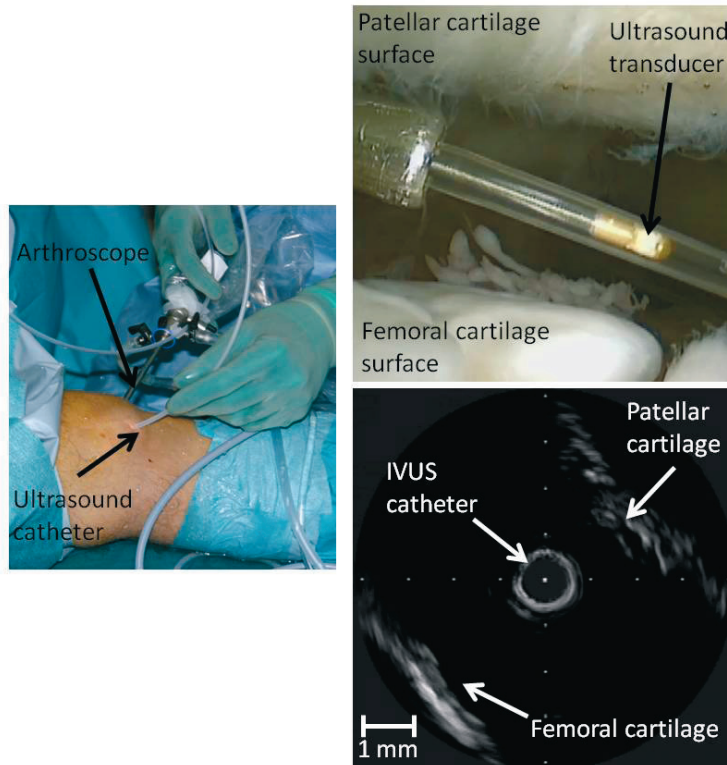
The *in vivo* measurement geometry. Ultrasound examination was carried out using the same anteromedial and anterolateral portals that were used in routine arthroscopy. The ultrasound transducer was guided to the measurement site with the help of the arthroscope. When the position of the ultrasound catheter was optimal (i.e., the maximum reflection was detected) ten full revolutions of the ultrasound probe were recorded and the revolution with the highest reflection was stored for later analysis. In addition to the ultrasonic data, a digital video from the arthroscopy was recorded through the arthroscope.
